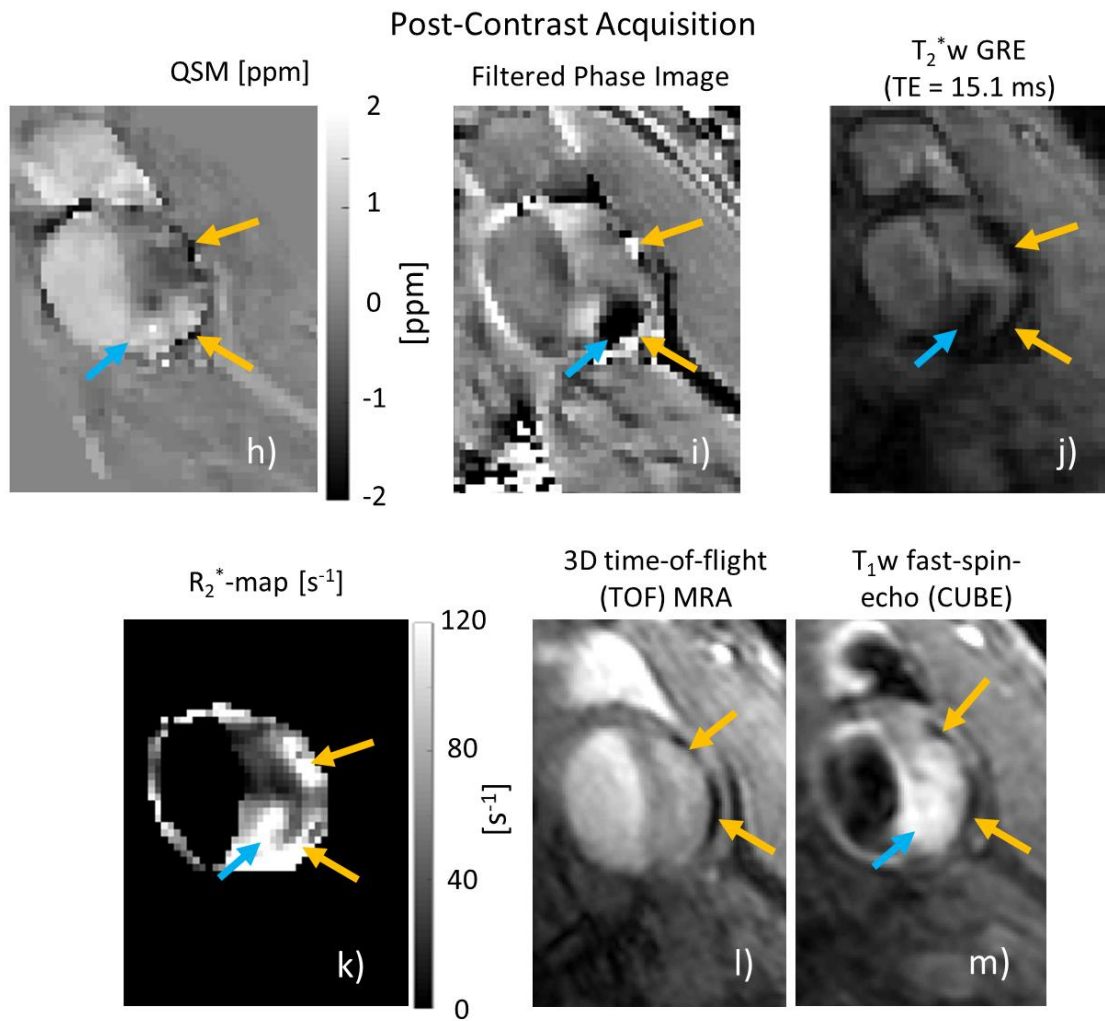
A 65-year-old man was scanned before (a-f) and after (h-m) contrast agent administration. Calcified regions are indicated by a yellow arrow. They appear hypointense on QSM (a, h),  $T_2^*w$  GRE (c, j), 3D TOF MRA (e, l) and  $T_1w$  FSE (f, m). They appear hyperintense on filtered phase images (b, i),  $R_2^*$ -maps (d, k), and CT (g). USPIO uptake is indicated by the blue arrows on the post-contrast images. USPIO-uptake appears hyperintense on QSM (h),  $R_2^*$ -maps (k), and  $T_1w$  FSE (m). It appears hypointense on filtered phase images (i) and  $T_2^*w$  GRE (j). (I also presented these results in the publication (305))
